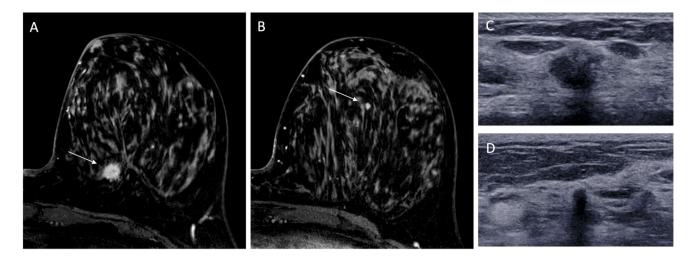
Contrast enhanced T1-weighted fat saturated breast MRI image showed a suspicious round mass with spiculated margins at 7:00 (A, arrow) and a separate suspicious oval mass with circumscribed margin at 12:00 (B, arrow). A targeted ultrasound demonstrated two masses corresponding to the MRI findings. There was an
